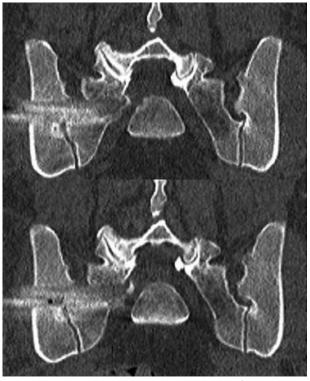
Pelvic CT coronal reconstructions confirming bony narrowing of right S1 foramen before second revision
